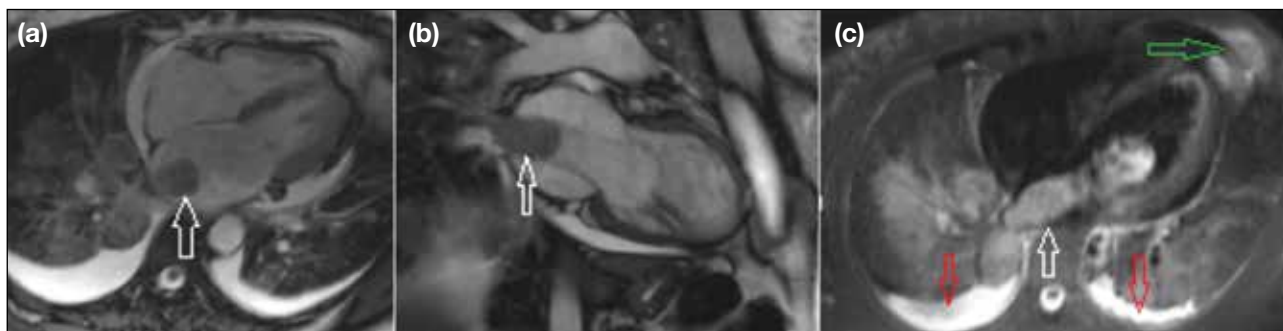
Cardiac magnetic resonance imaging of a 49-year-old female patient with a diagnosis of gastric carcinoma with multiple bone metastases. The images showed the same lesion at different sequences, which is a mass attached to the left atrial wall and extending into the atrial cavity that was considered to be gastric cell carcinoma metastasis (white arrows). Bilateral pleural effusions and left costal metastases (green and red arrows) are shown in (c). (a) Four-chamber cine steady-state free precession gradient echo sequence. (b) Two-chamber cine steady-state free precession gradient echo sequence. (c) Axial T2-weighted triple inversion turbo spin echo sequence.
